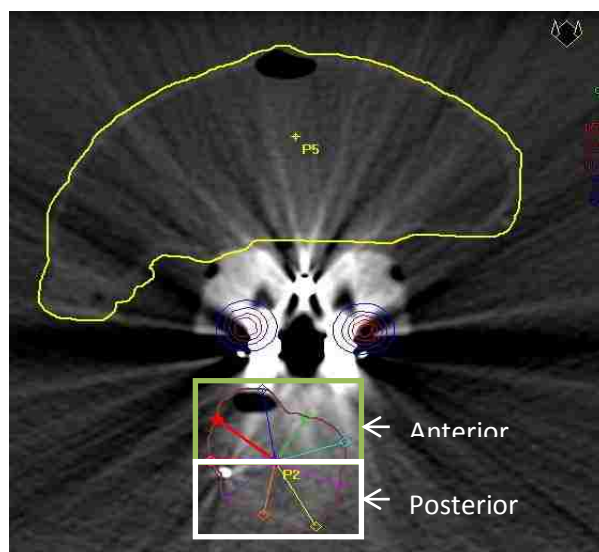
Axial CT slice of the FW shielded ovoids demonstrating the anterior and posterior artifact regions as well as the decrease in metal artifact with distance from the high Z objects.
